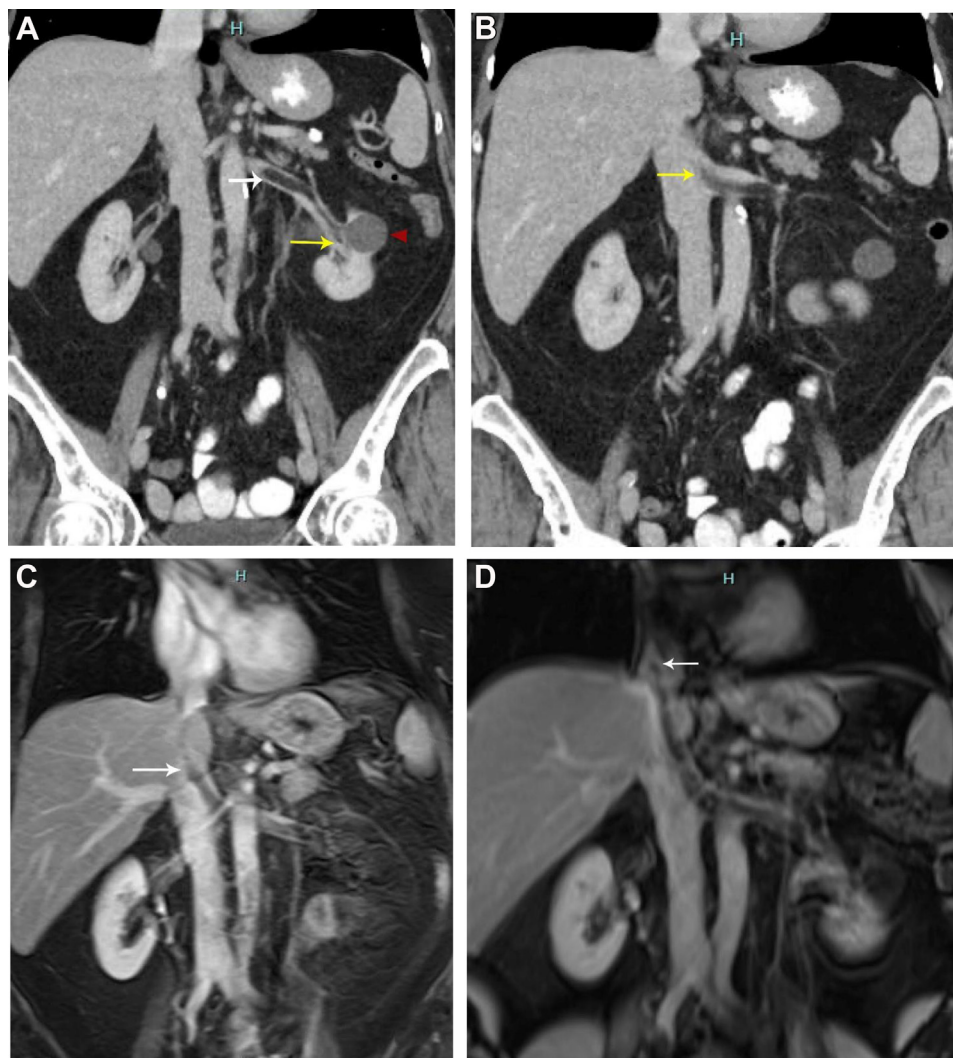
Imaging findings of the primary intravascular lipoma. A, Initial contrast-enhanced computed tomography (CT) scan showing a coronal section of a homogenous low-density tumor within the left renal vein (*white arrow*) with its origin (*yellow arrow*). A left renal cyst (*red arrowhead*) can also be seen. B, View of intravascular lipoma growing into the inferior vena cava (IVC; *yellow arrow*) on initial contrast-enhanced CT scan. C, Initial magnetic resonance image showing a fat-attenuating mass extending into to the perihepatic IVC (*white arrow*). D, Follow-up magnetic resonance venography showing extension of the mass into the inferior cavoatrial junction (*white arrow*).
